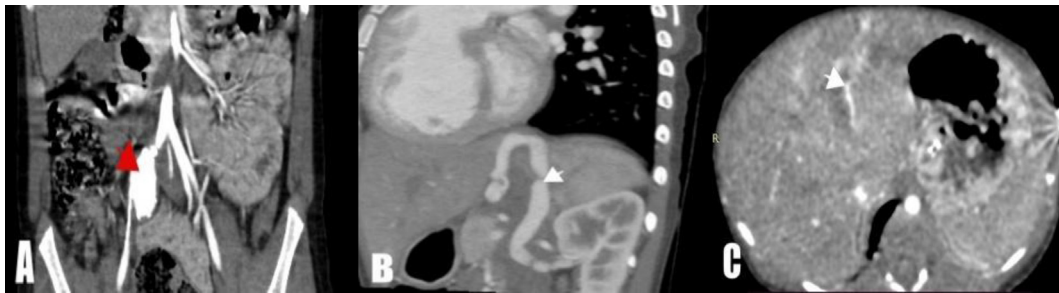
Example of Vascular findings: (a) Coronal reformatted multi-slice computed tomography image showing a well-defined fusiform aneurysm in the right common iliac artery (arrowhead) extending to its bifurcation, note that right internal iliac artery is occluded. (b) a- 5 years old patient presented with severe Tricuspid regurgitation (TR) and severe pulmonary hypertension, Sagittal oblique reformatted multi-slice computed tomography shows dilated tortuous venous channel (arrowhead) from proximal portal vein to left renal vein, suggestive of type 2 extracardiac congenital portosystemic shunt (CPSS). (c) A 2-month-old patient presented with pulmonary atresia, axial multi-slice computed tomography shows a marginally enhancing track along the course of umbilical vein with noted hypodensity inside (arrowhead) impressive of umbilical vein thrombosis. MSCT: multi-slice computed tomography, TR: tricuspid regurgitation and CPSS: congenital portosystemic shunt.
